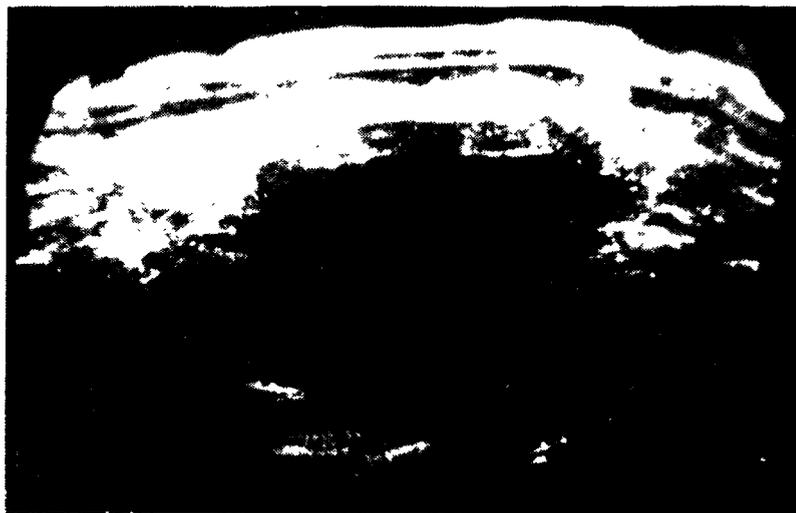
Multiple fibroids, showing progressive attenuation of ultrasound, with only faint echoes from posterior surface of mass in contrast to ovarian cysts.
